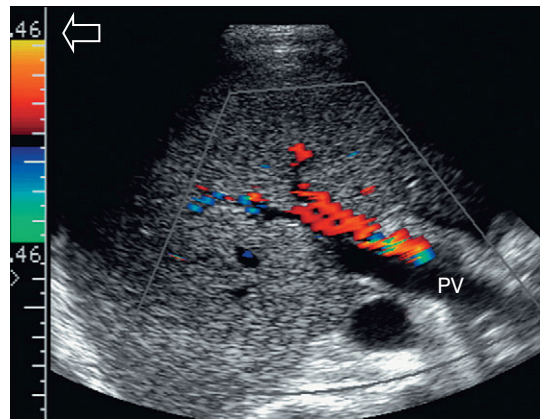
Colour Doppler image along the axis of the porta hepatis in a patient with portal hypertension. Colour flow is clearly evident in the hepatic artery. The portal vein, however, shows no evident flow suggesting thrombosis. Evaluation of the pulse repetition frequency (arrow) shows that the value was set quite high. This effectively suppresses colour display of slow flow giving the false impression of thrombosis.
